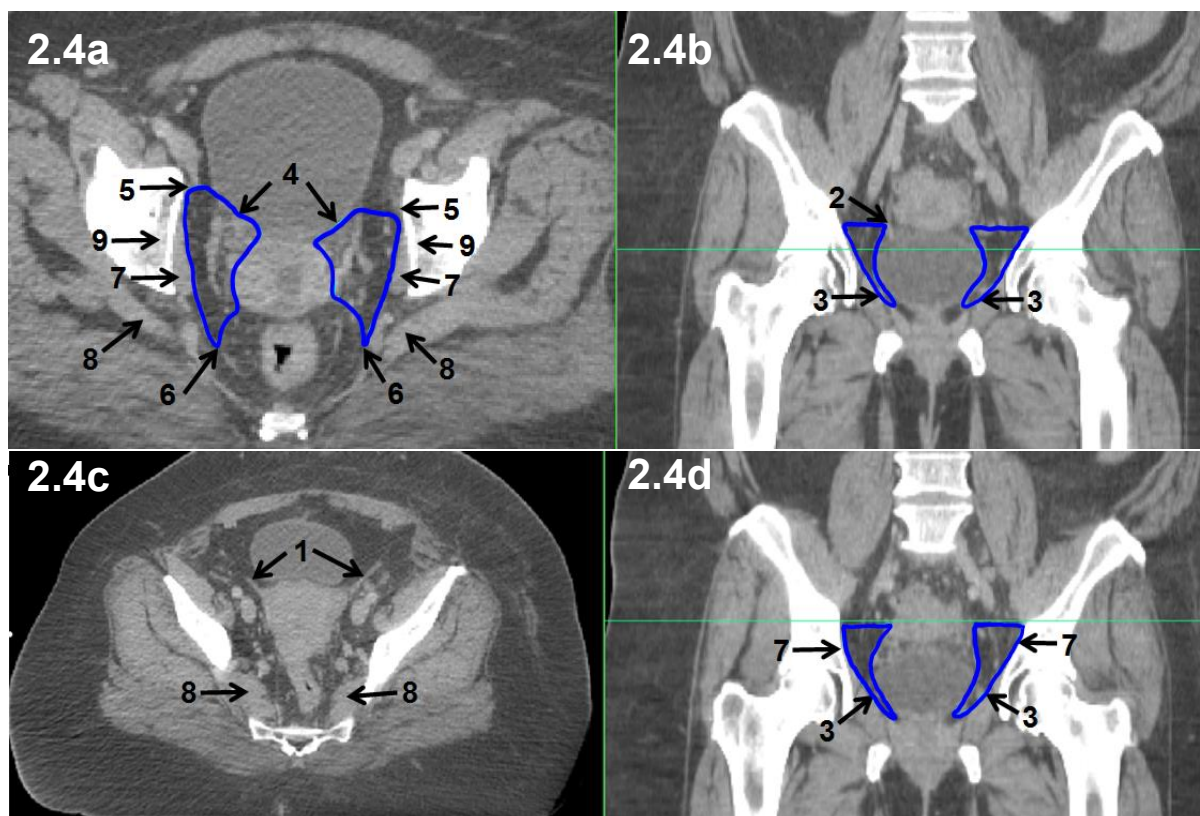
Transverse (a and c) and coronal (b and d) CT with both parametrial borders outlined; see Table 1.
